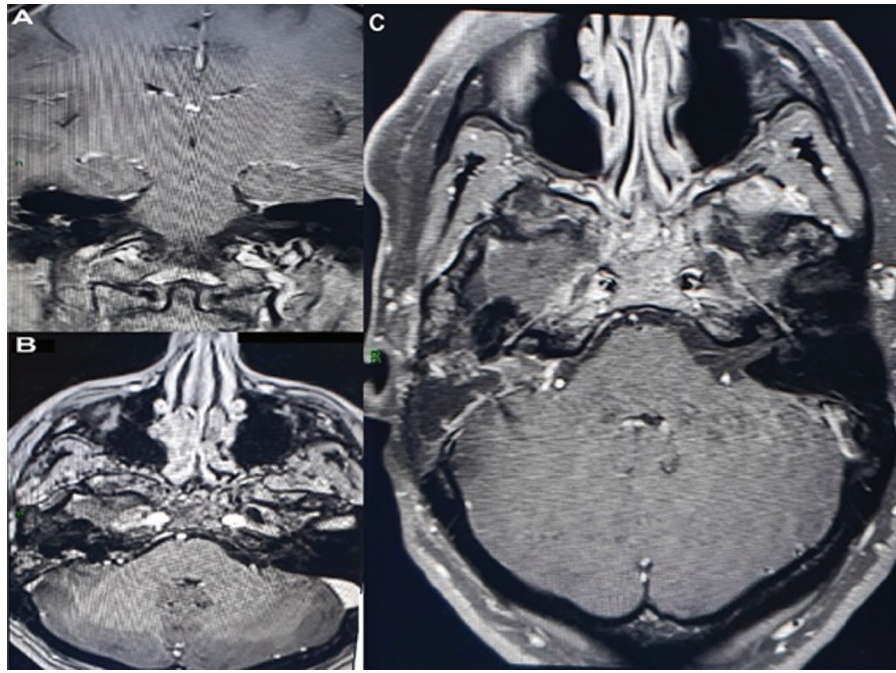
Postoperative MR showing no residual tumor within the internal acoustic canal. (A) T1 weighted gadolinium-enhanced coronal image. (B) T1-weighted gadolinium-enhanced axial image. (C) T1-weighted image, no gadolinium. Notice signs of mastoid manipulation (petrosectomy). MR, magnetic resonance.
